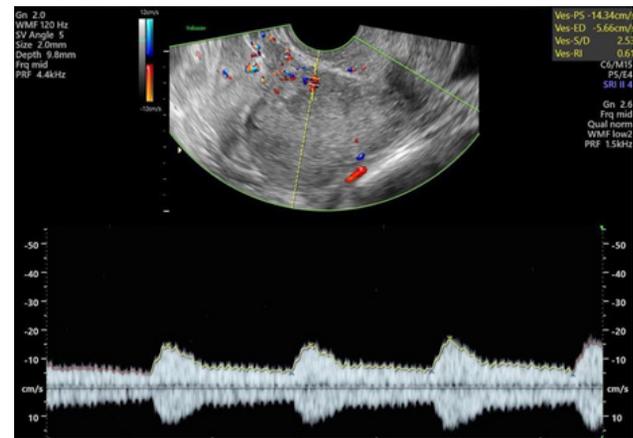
Arcuate vessels Doppler; a sagittal view of the uterus with color Doppler visualizing the uterine vessels within the myometrium.
